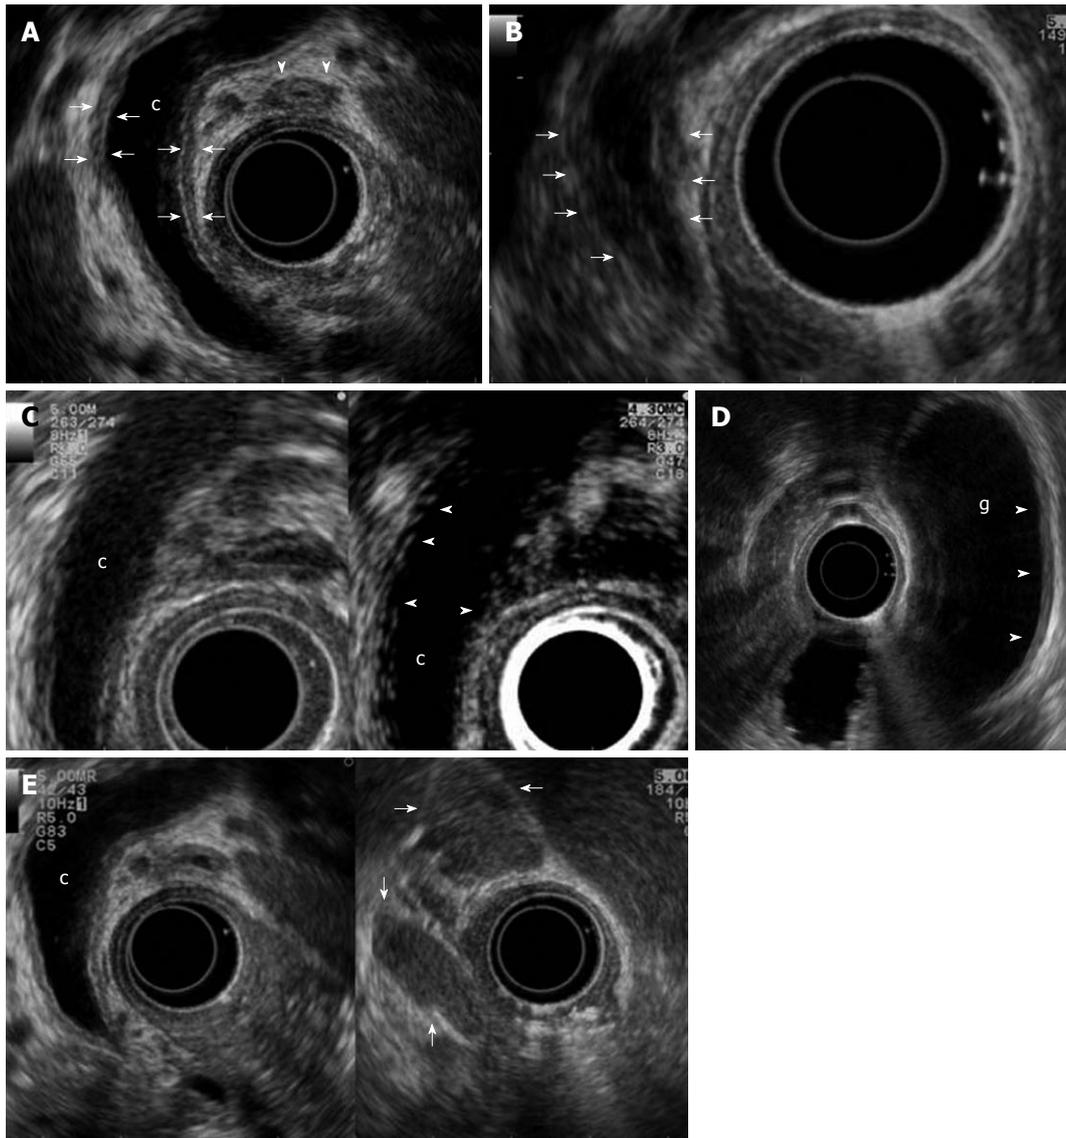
Biliary and peripancreatic findings in autoimmune pancreatitis. Autoimmune pancreatitis presenting with jaundice: A: Endoscopic ultrasonography (EUS) shows a dilated common bile duct (c) upstream to a distal funnel-shaped stenosis; EUS demonstrates the diffuse thickening of the biliary wall (between arrows) with "sandwich-pattern", either of common bile duct or of cystic duct (arrowheads). This thickening is equally visible both in the dilated region of the common bile duct; B: In the distal strictured tract (arrows); C: After contrast administration (Sonovue, Bracco) the biliary wall shows an early and persistent enhancement (arrowheads); D: EUS shows the same thickening of the gallbladder (g) wall (arrowheads); E: Enlarged lymph nodes to the hepatic hilum (arrows).
